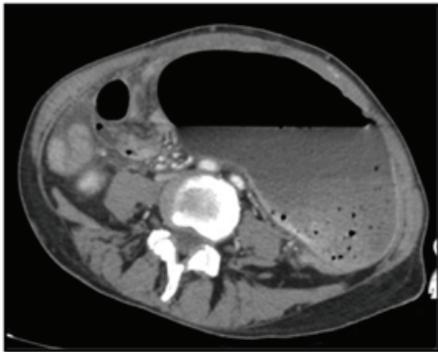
Axial plane on CT scan.
